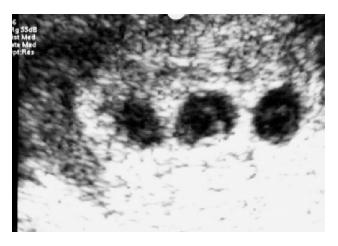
Sonogram demonstrating three gestational sacs at 6–7 weeks. Two sacs contain an embryonic pole with positive heartbeat, whereas the left sac is empty (i.e. blighted ovum). Image courtesy of Yuval Or
